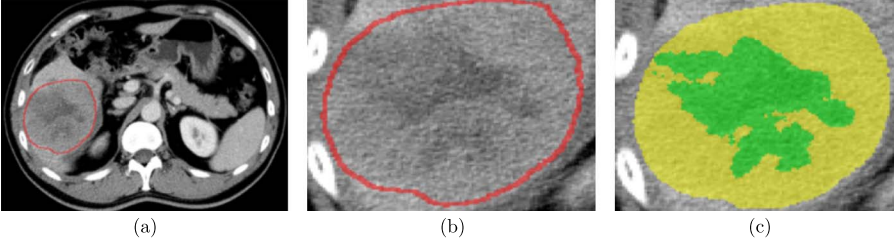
(a) represents the CT image slice (PV phase). (b) represents the ROI (segmented lesion), which is checked by two experienced experts. (c) represents the label map, in which each pixel was assigned with a class label represented by different color.
